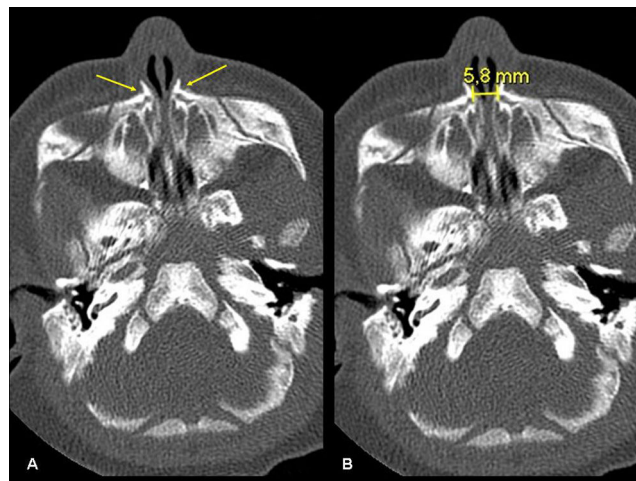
Axial CT section of the paranasal sinuses without intravenous contrast. Abnormal medial approximation and thickening of the nasal processes of the maxilla are observed (A, arrows), representing an abnormally narrow pyriform aperture of 5.8 mm (B).
